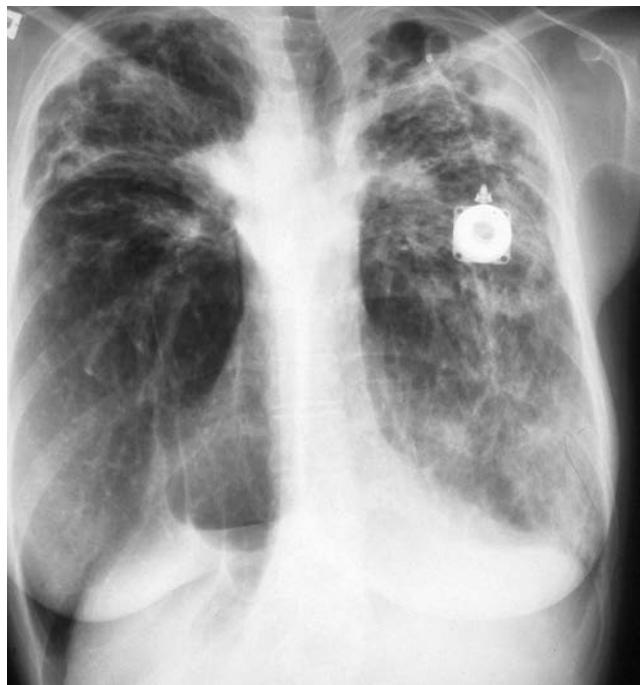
Chest radiograph of a patient with cystic fibrosis for bilateral lung transplantation. The chest image shows a typical pattern of bronchiectasis. A subcutaneous intravenous injection reservoir is seen over the upper left chest.
